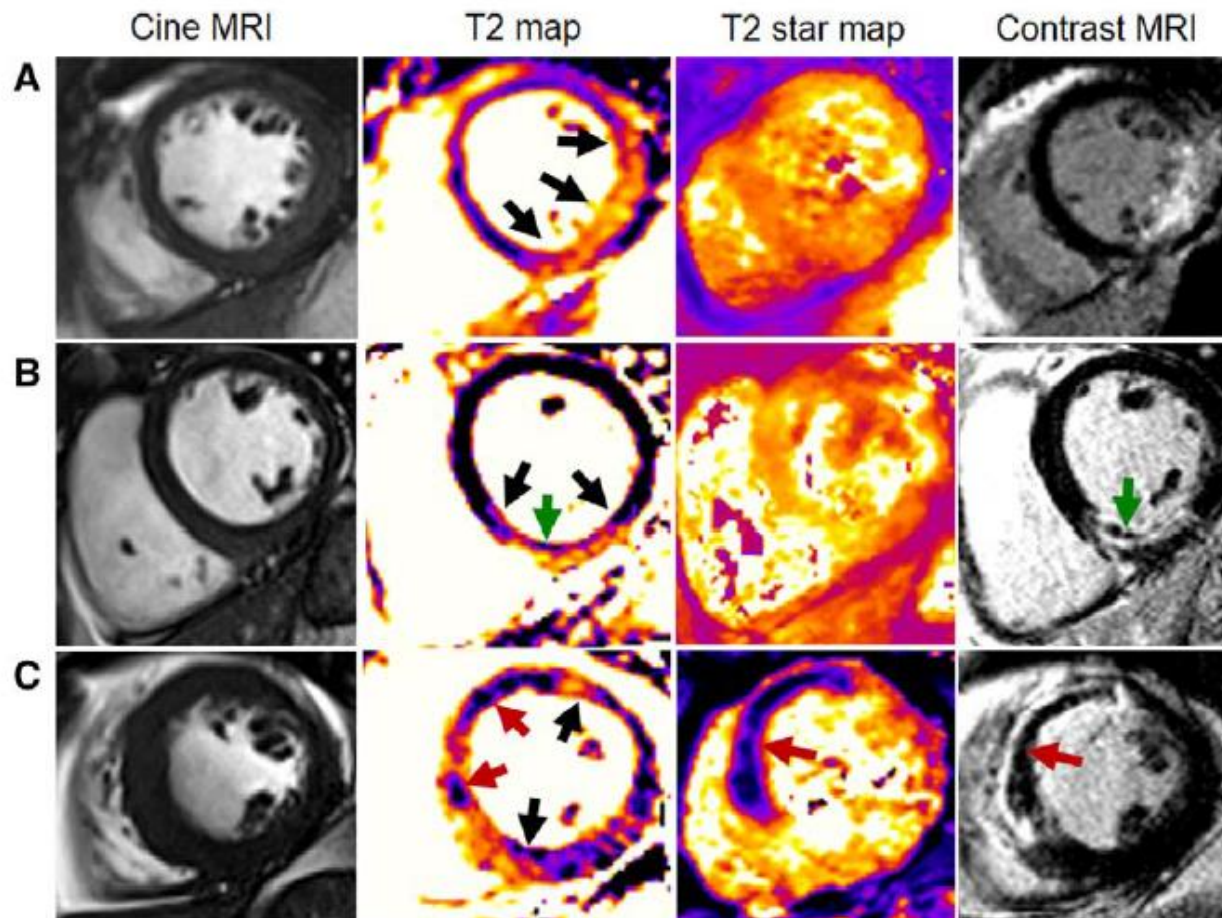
Three patients with acute ST-segment-elevation myocardial infarction treated by primary percutaneous coronary intervention (PCI) using the same antithrombotic strategies. Each patient had normal thrombolysis in myocardial infarction grade 3 flow at the end of PCI. Cardiac magnetic resonance imaging was performed 2 days post reperfusion. A, Patient with no evidence of myocardial hemorrhage or microvascular obstruction. B, Patient with T2-hypointense core and microvascular obstruction, in the absence of hemorrhage. C, Patient with myocardial hemorrhage (Results section in the Data Supplement).
